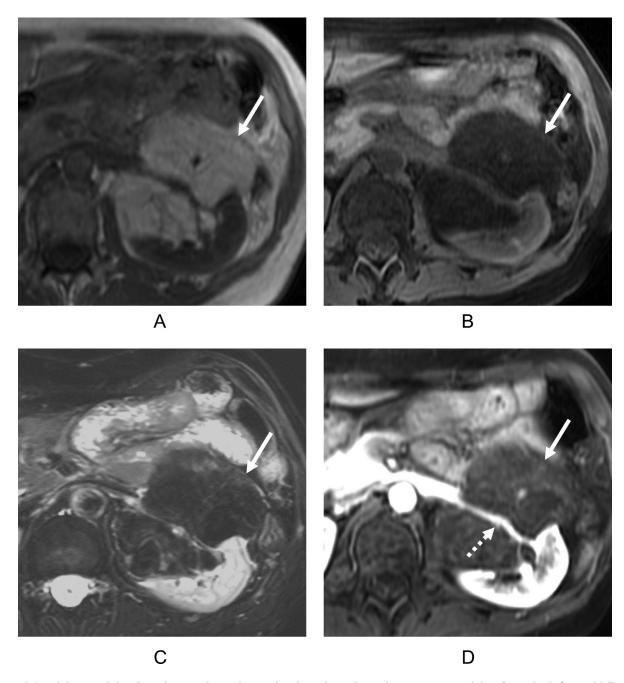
(A) Axial T1-weighted MR image showed a predominantly T1 hyperintense mass arising from the left renal hilum (arrow), with loss of signal on (B) axial T1-weighted fat-suppressed MR image (arrow), compatible with lipomatous tumor. (C) Axial T2-weighted fat-suppressed MR image showed a predominantly hypointense left renal hilar mass due to suppression of fat signal (arrow). A few T2 hyperintense thin internal septations were present. (D) Axial IV contrast-enhanced fat-suppressed T1-weighted MR image showed a heterogeneous enhancement of the mass arising from left renal hilum (arrow) with encasement and stretching of the left renal vasculature (dashed arrow).
